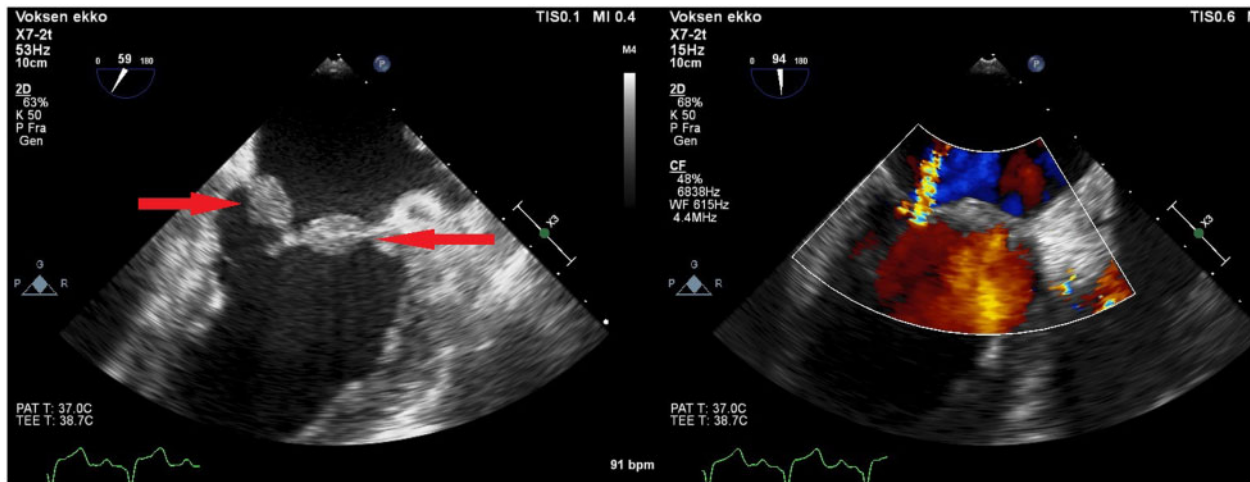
Transesophageal echocardiogram of the mitral valve. Vegetations are nodular shaped, tightly attached to the surface of the valve, and without independent movement.
